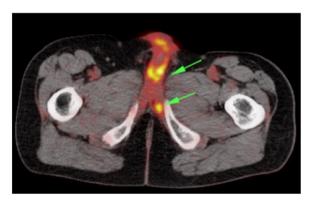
Positron emission tomography/computed tomography imaging with fluorodeoxyglucose (FDG)-avid lesions in case 2. Multiple FDG-avid foci are evident in the penis (green arrows). A total penectomy was performed to palliate local symptoms (pain).
